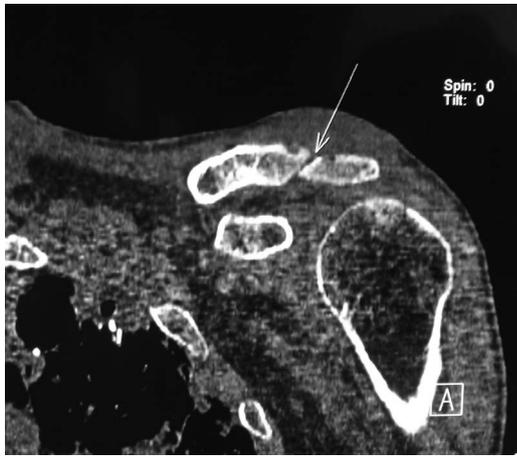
CT scan of the left acromioclavicular joint showing the marked joint space narrowing.
